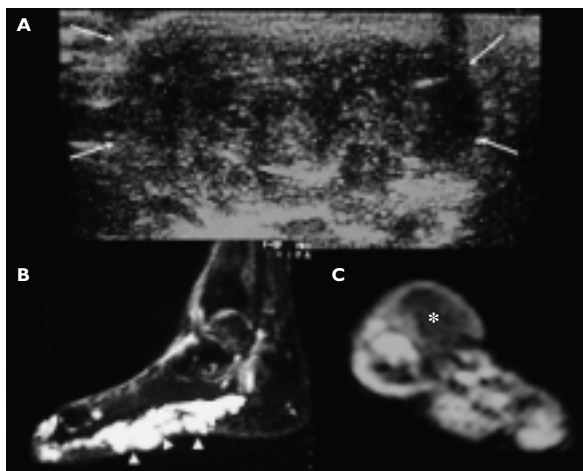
(A) Sonography depicted solid masses (arrows); (B) T2-W sagittal MRI scan. Multiple, lobulated hyperintense masses in peritendinous, subcutaneous areas and under plantar fascia (arrowheads); (C) After gadolinium injection T1-W axial scan. Peripheral rim enhancement was seen on masses (asterix).
